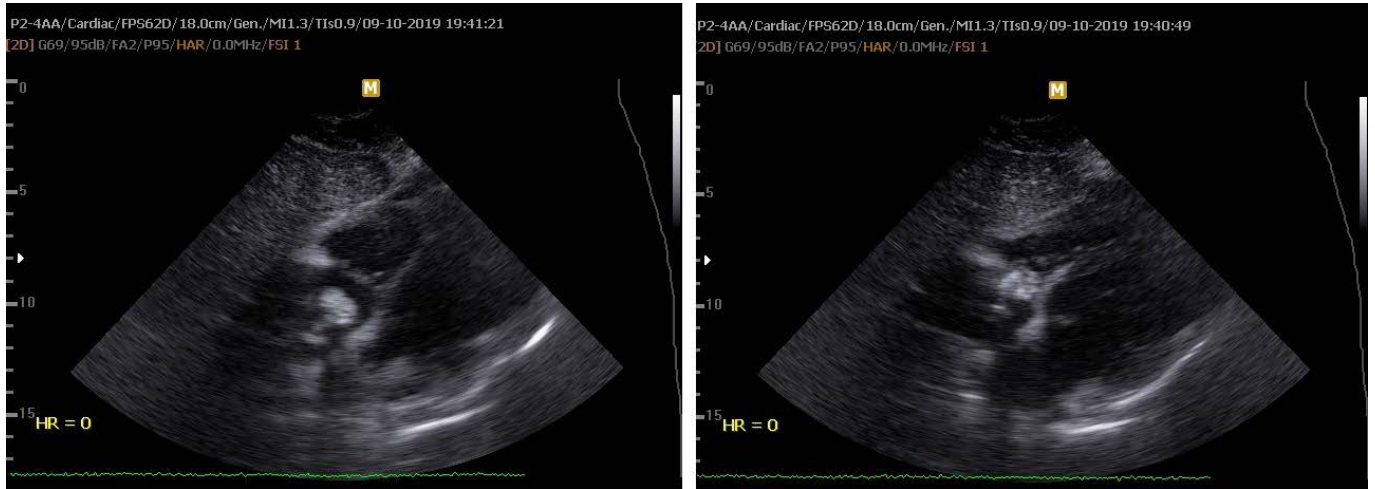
Images of transthoracic echocardiography, subcostal view, showing an inhomogeneous mass in the right atrium that prolapses in the right ventricle during diastole
